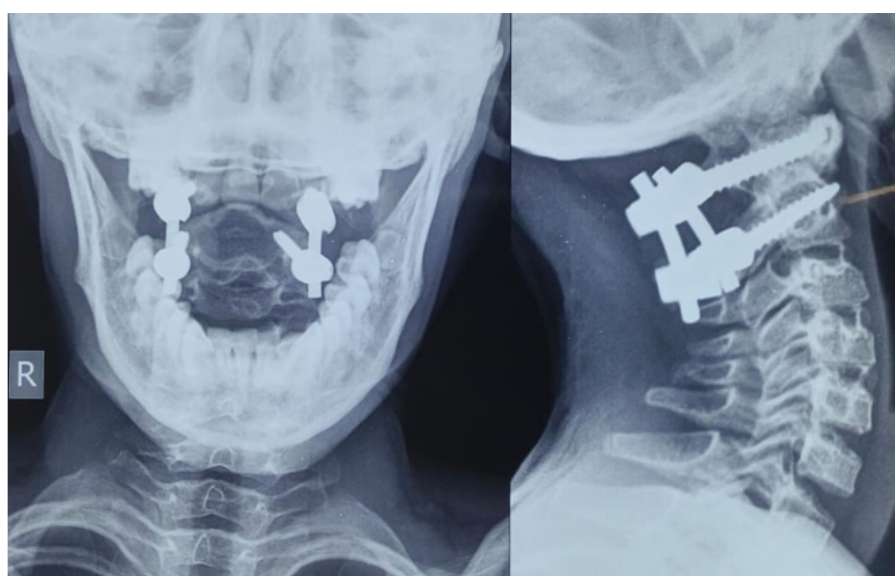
Post operative radiograph of C1-C2 construct
